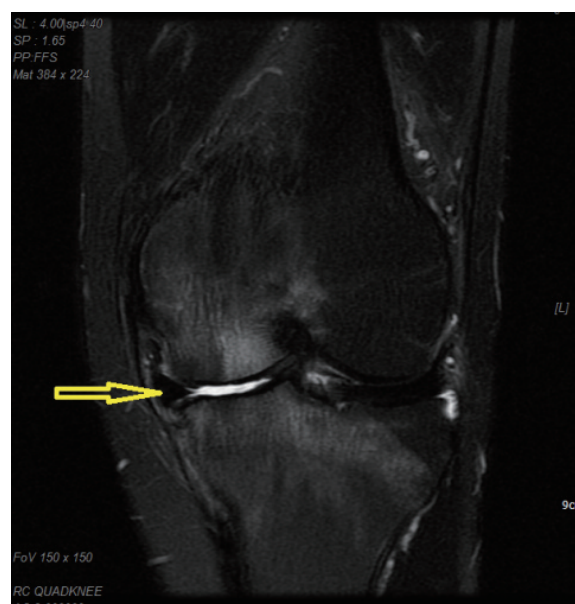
Left knee MRI of case 3 (12/24/2016)
